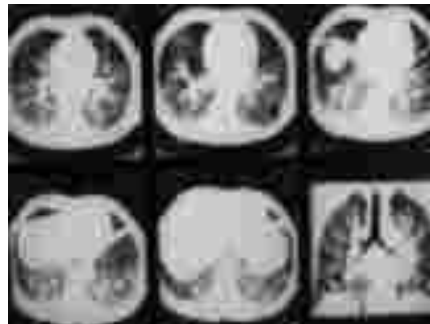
Computed tomography of the chest. Pneumonic form of lung cancer
